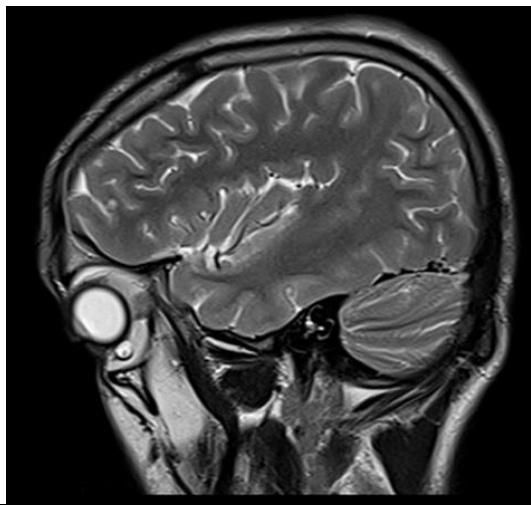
MRI Brain: Saggital T2W: Showing well defined hyperintense signal in orbit with eccentric hypointense signal.
